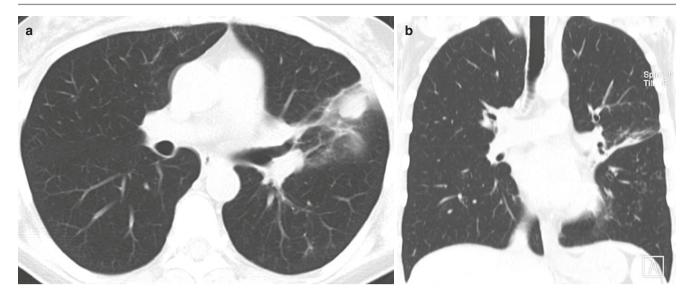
A 59-year-old woman with coccidioidomycosis. (a, b) Axial and coronal CT images in lung window show a nodular lesion with surrounding ground-glass opacities and "tree-in-bud" opacities in the left lower lobe
